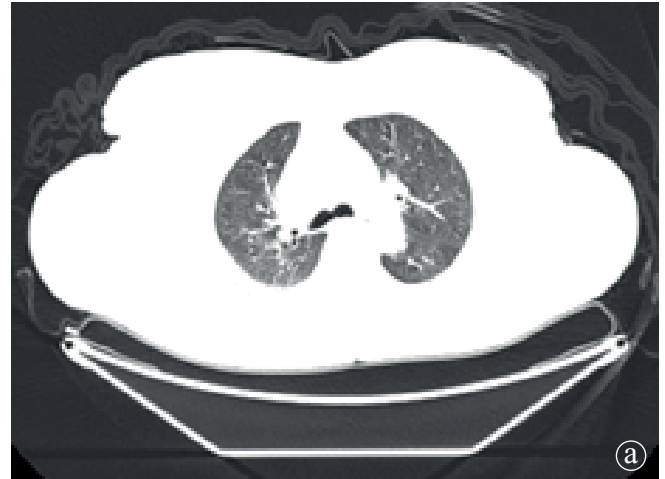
a) CT, b) PET and c) fusion PET/CT axial slices of the initial scan showing a focal high FDG avid (SUVmax – 30.7) area in upper lobe of left lung without any obvious CT detectable lesion.
